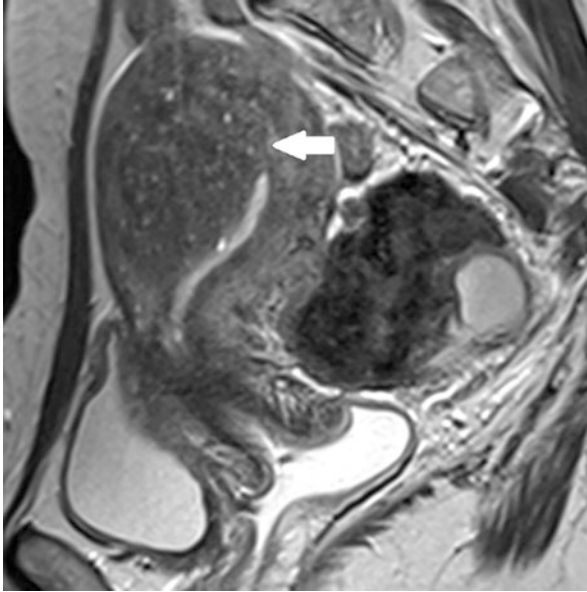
Adenomyosis. Sagittal T2-weighted MR shows diffuse thickening of the junctional zone up to 14 mm, consistent with adenomyosis
